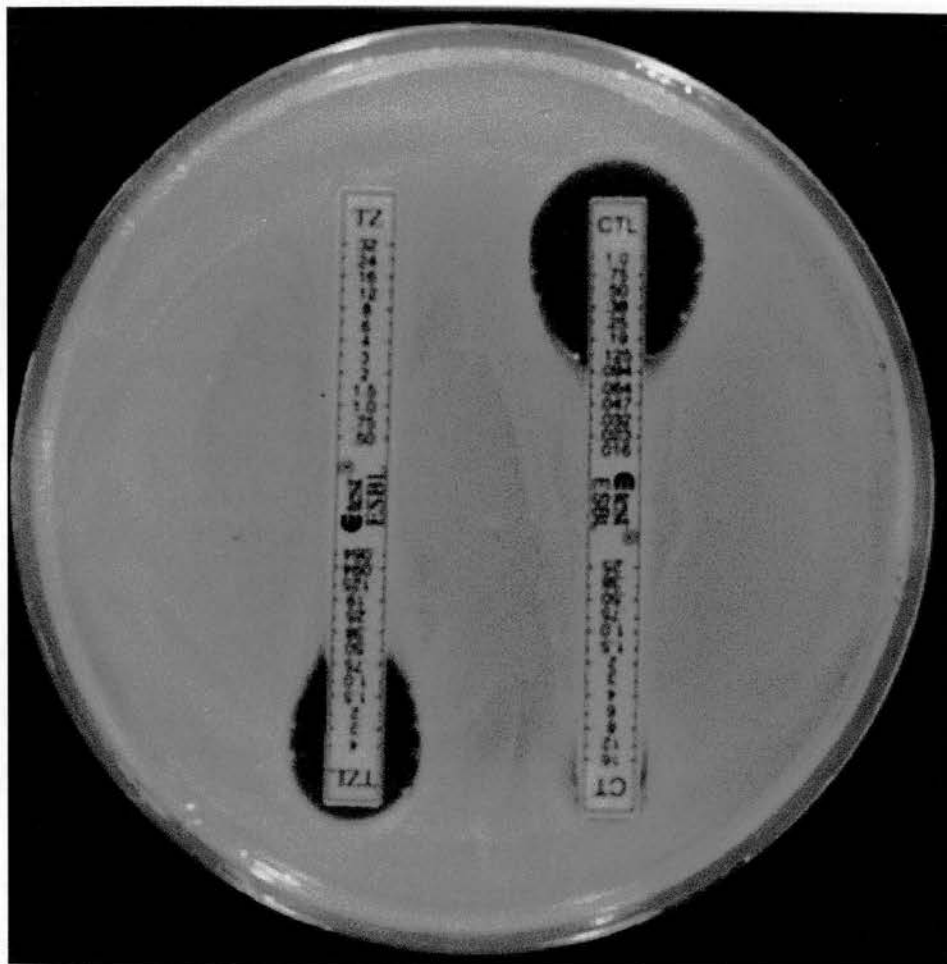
Plate showing positive ESBL reaction with E-test strips containing cefotaxime + cefotaxime/clavulanic acid (CT/CTL) and ceftazidime + ceftazidime/clavulanic acid (TZ/TZL). The zone of inhibition is read on the two halves of each strip where the inhibition ellipse intercepts the strip.
